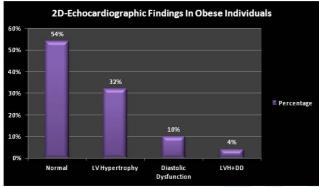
2D Echocardiographic Findings In Obese individuals
